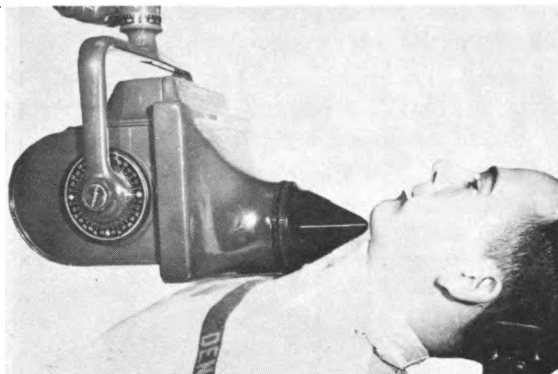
Tube and patient position for mandibular occlusal roentgenogram.
